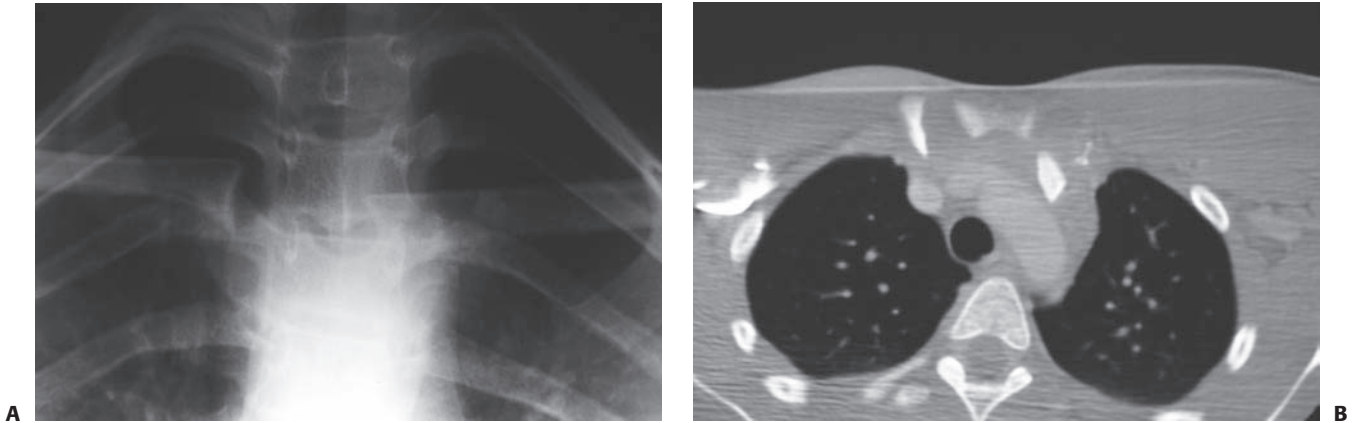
A: Serendipity radiograph showing a left posteriorly dislocated sternoclavicular joint. Note that the affected side appears inferiorly displaced. B: CT scan of the same patient clearly showing the left posterior dislocation.
